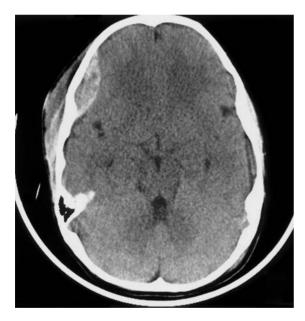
Axial CT reveals a small right frontal subacute epidural haematoma with mixed hypodense and hyperdense component, concomitant extracranial haematoma.
